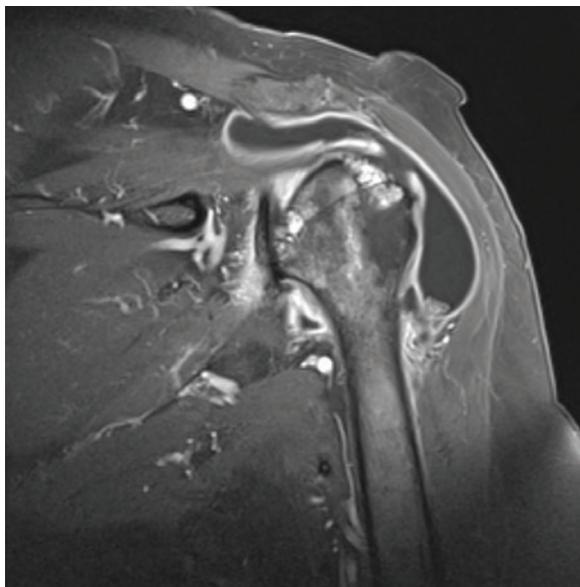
Subacromial bursitis in MRI, T1 TSE FS CM
